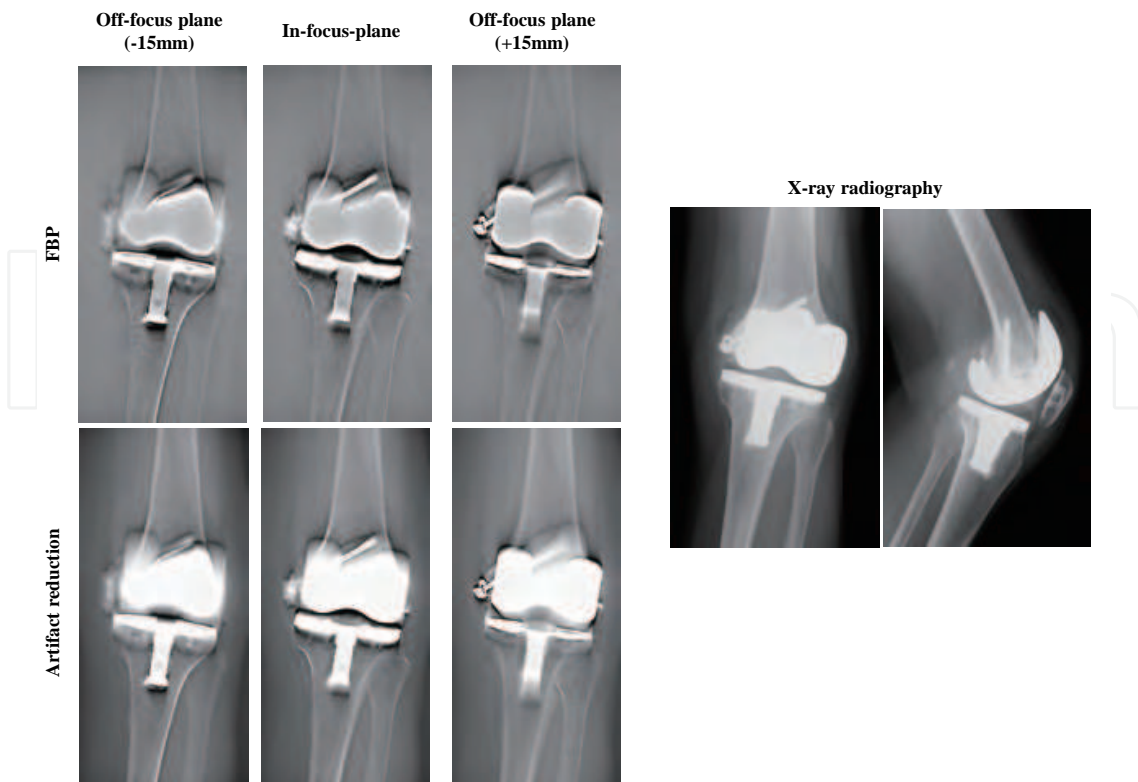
Case 2 patient (71-year-old woman; Gonarthrosis, post total knee arthroplasty; TKA). AP radiographs of the knee joint prostheses are demonstrated. AP radiograph is difficult to visualize 3D information in an AP radiograph as shown. The use of artifact reduction tomosynthesis ($w=0.06$) allowed better visualization of the prosthesis caused by the blurring of anatomic structures above and below the visualized planes.
